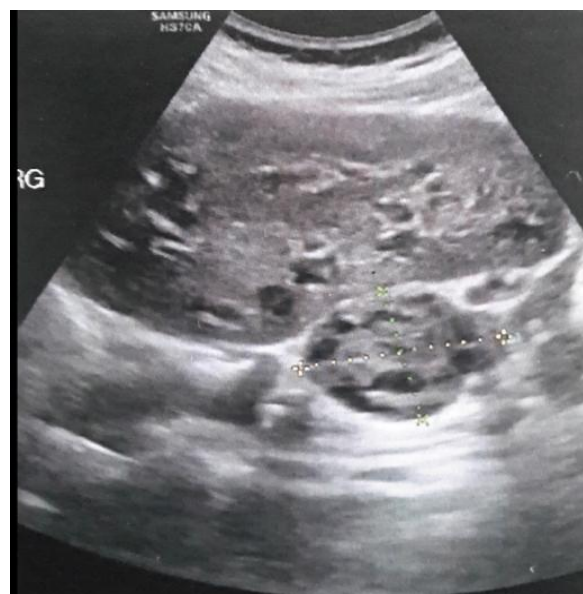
Ultrasound: left prerenal, rounded, heterogeneously echogenic tissue mass measuring 5 cm long axis
